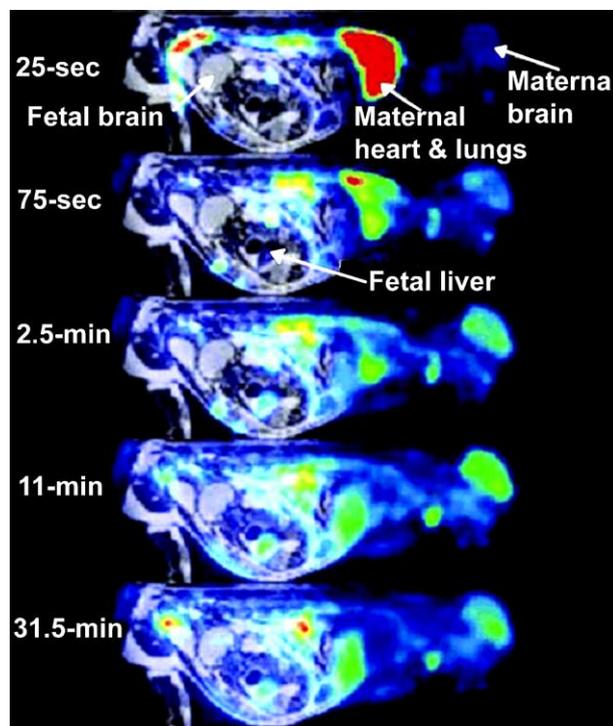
Time series of ^{11}C -cocaine positron emission tomography (PET) scans from third-trimester pregnant *Macaca radiata*. Each PET frame is coregistered to corresponding MR image. Early PET frames (25 sec, 75 sec, and 2.5 min) clearly show early ^{11}C uptake in placental vessels, maternal heart, lungs, and kidneys. Later time frames demonstrate uptake in fetal liver (Benveniste et al., 2005). Reprinted with permission.
